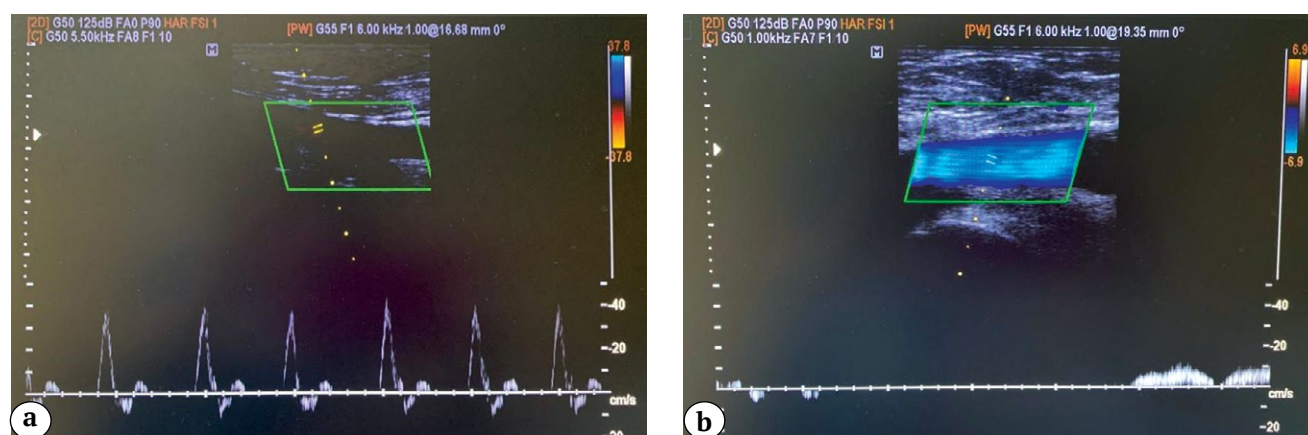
Ultrasound duplex scanning (control study after 12 months): a — superficial femoral artery; b — common femoral vein
